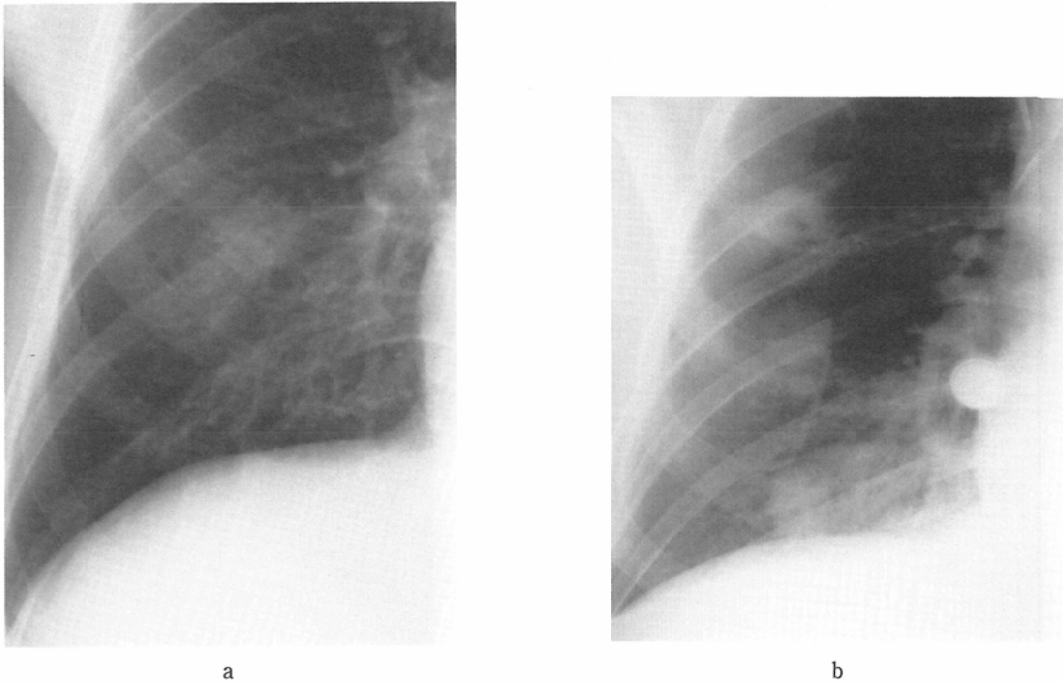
(Case 5) Aspergillus infection. PA chest radiograph 7.3 months after cardiac transplantation shows a focal round nodule in the right lower lung (a), leading to multiple cavitary nodules on a AP portable chest radiograph in a week (b).
